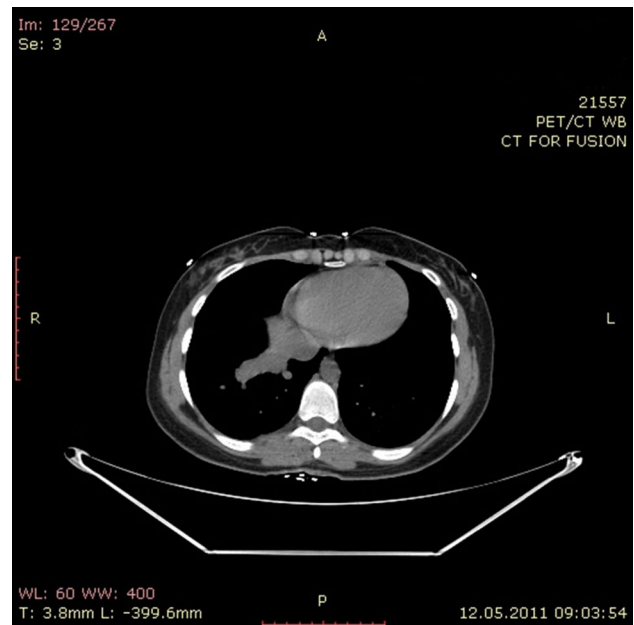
Contrast-enhanced PET/CT images (maximal intensity projection, and 3D volumetric images) show an anomalous right lower lobe pulmonary vein descending vertically, draining the right lower lobe and entering the inferior vena cava
